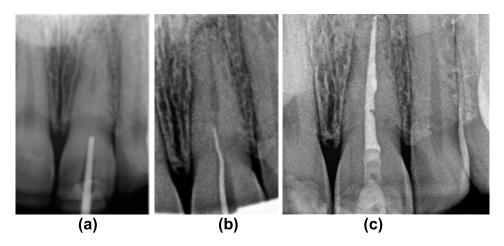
Radiographic examination was used to confirm (a) correct path of access pathway during procedure and (b) correct root canal access; (c) postobturation radiograph.
